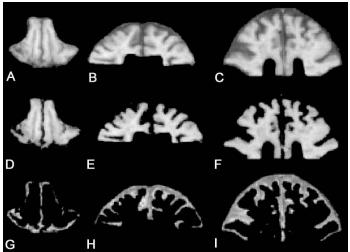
Regional brain atrophy measurement of the frontal lobes in a patient with relapsing-remitting multiple sclerosis. (a), (b) and (c) shows masked T1-weighted images of the frontal lobes segmented at various levels and obtained by semiautomated iterative morphologic outlining of the external cerebrospinal fluid (CSF) spaces; the next six images show the result of segmentation: (d), (e) and (f) are brain parenchyma-only images and (g), (h) and (i) are CSF-only images.
